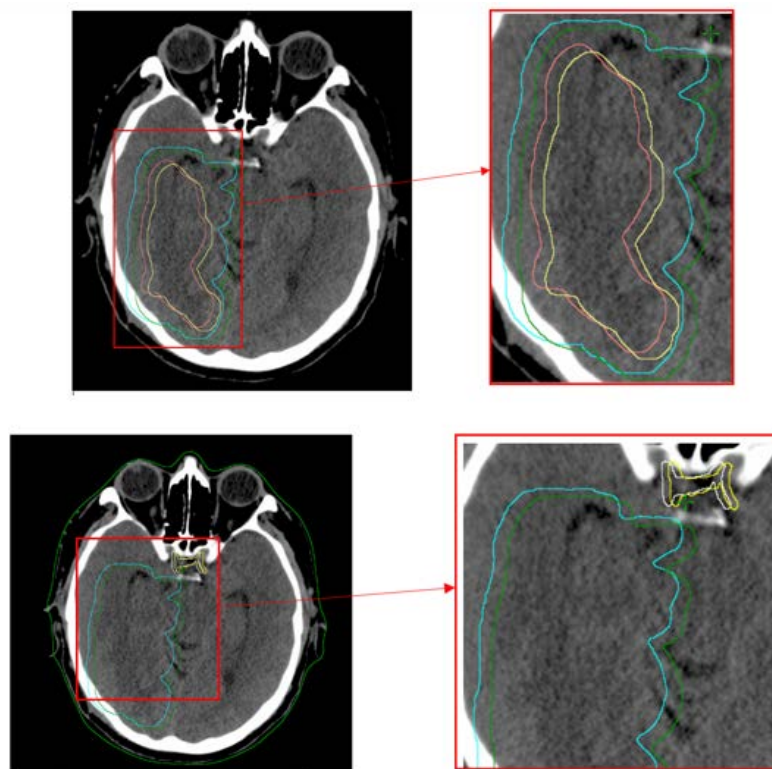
2D images showing difference between Glioma's (PTVs and Oedema in 1<sup>st</sup> row) (PTV's and Chiasma in 2<sup>nd</sup> row) delineated on CT and on MRI images.
